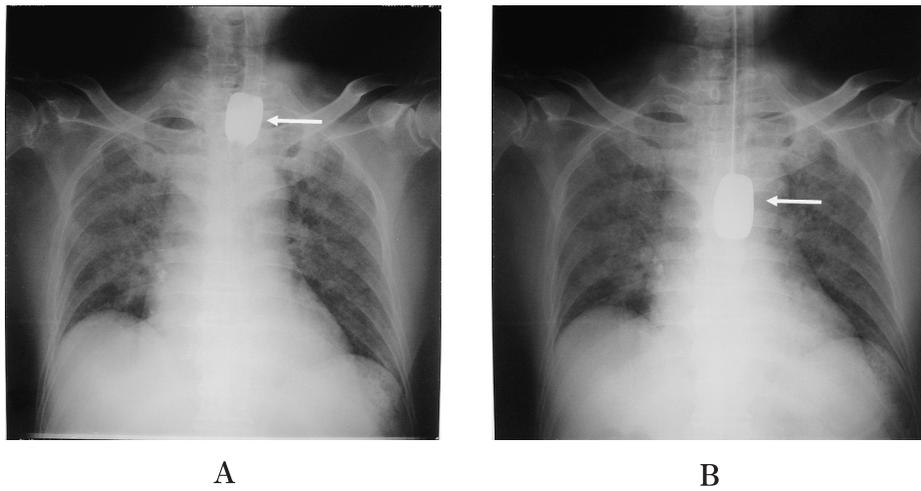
A chest X-ray radiograph of case No. 1 with the intubation of the ECT and WB
